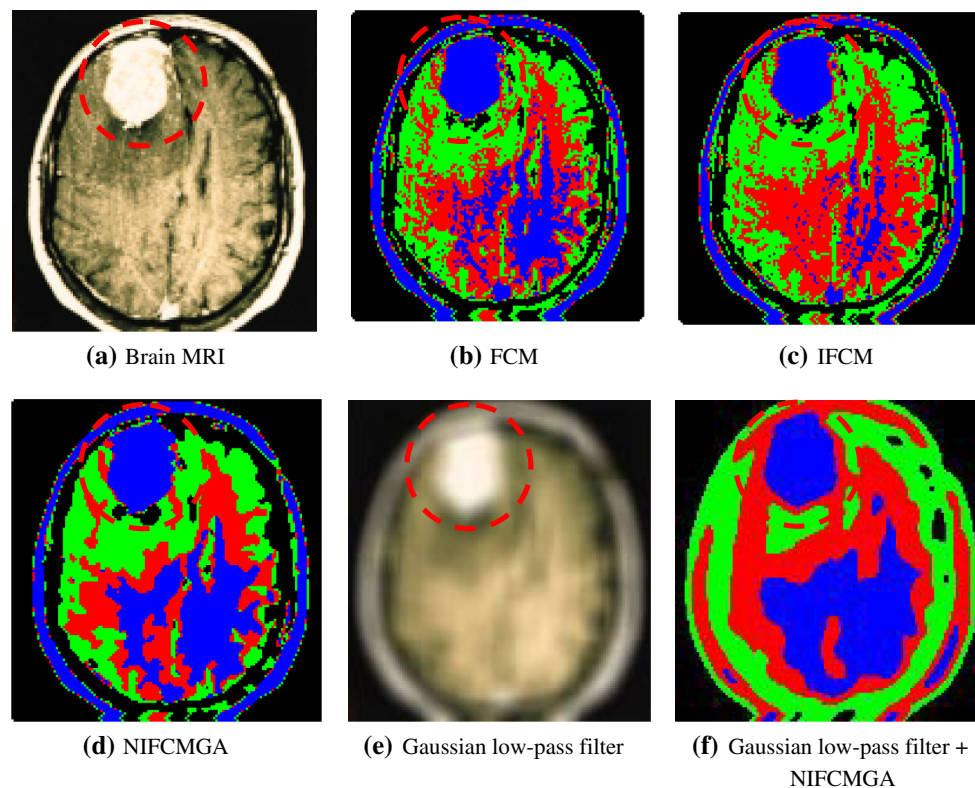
Experimental results of brain tumor MRI with various clustering methods
